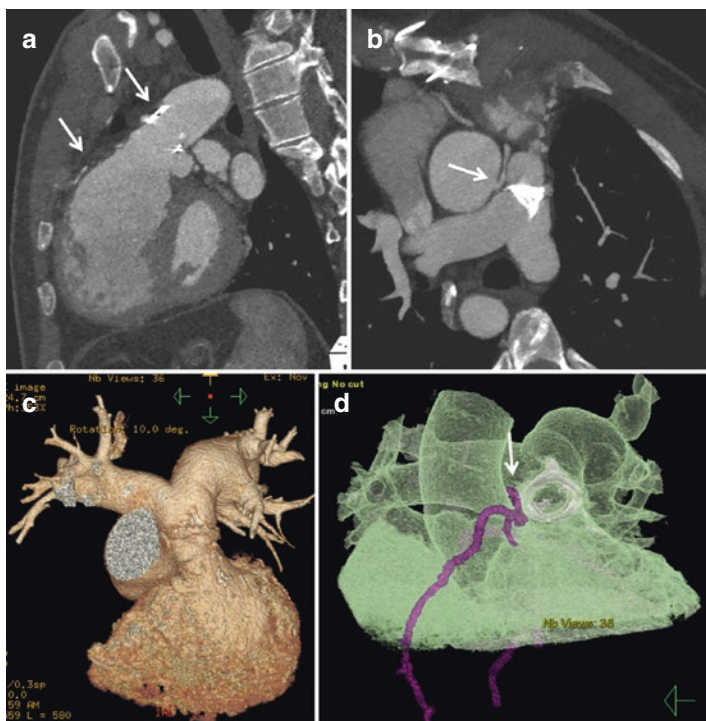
Preoperative coronary artery assessment prior to valve repair. Reformatted CT angiography along the RVOT shows aneurysmal dilation of the outflow tract with a bioprosthetic pulmonary valve. Oblique reformatted MIP image (b) shows an anomalous aortic origin of RCA in close proximity to the RVOT/Valve. Volume rendered images augment visualization of anatomy in three-dimensional space (c) with depiction of close relationship of RCA (purple shading) and valve (white shading) (d)
